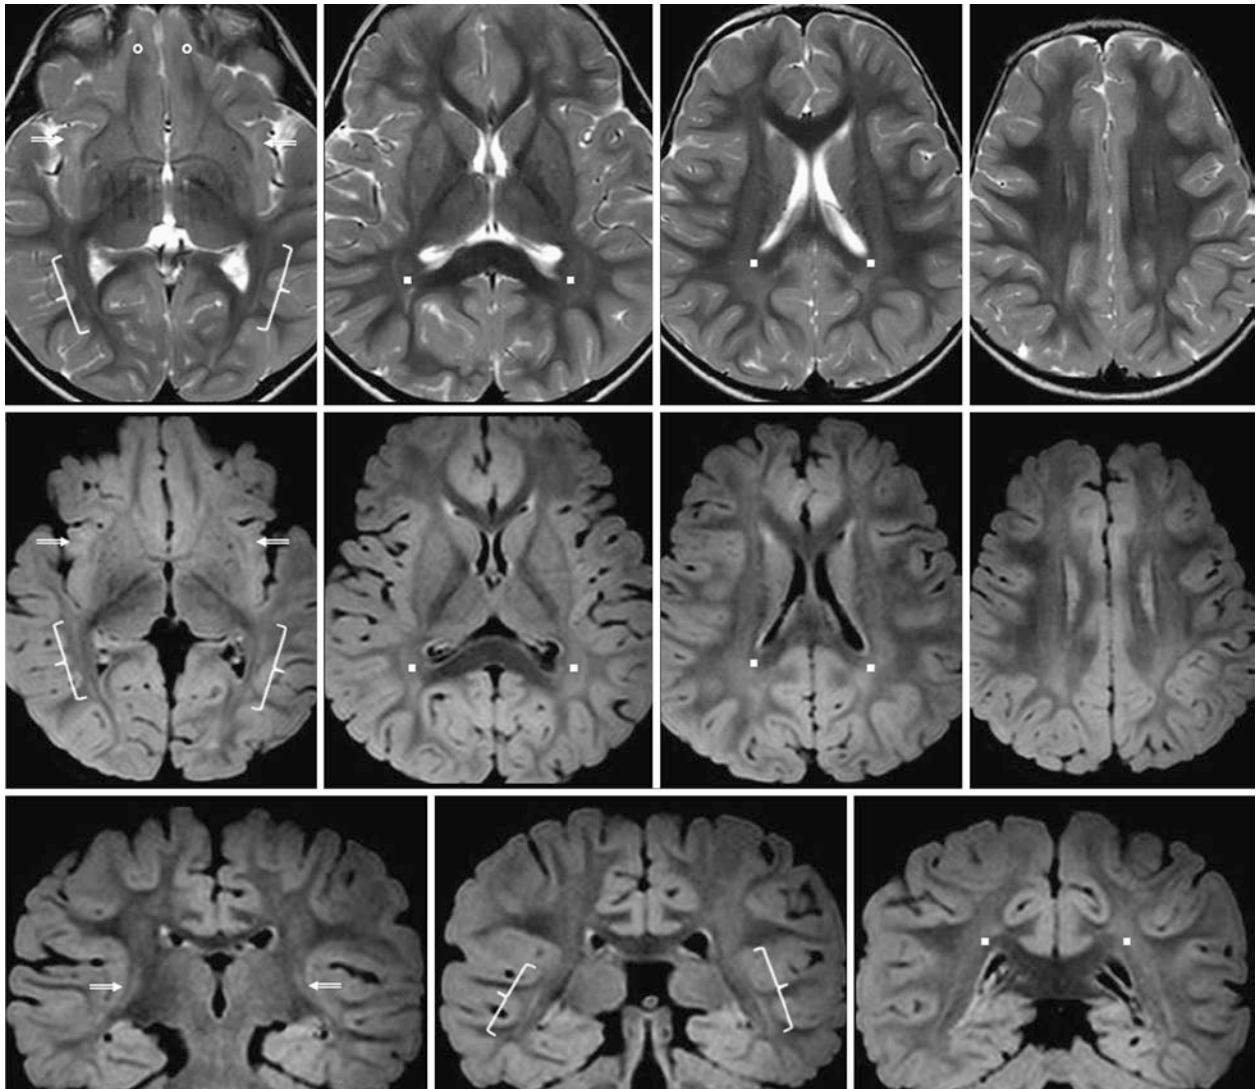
A 2.25-year-old with seizures after trauma had a normal 3T MRI. *Top row:* On SE T2WIs, note residual terminal zones within the SIWM (*beveled arrows*) and optic radiations (*brackets*). The ATWM and OFWM (*circles*) appear mature. Note normal PTWM terminal zones (*squares*) as well. *Middle row:* On 3D axial FLAIR images, the terminal zones mentioned above are slightly bright, but do not appear as
